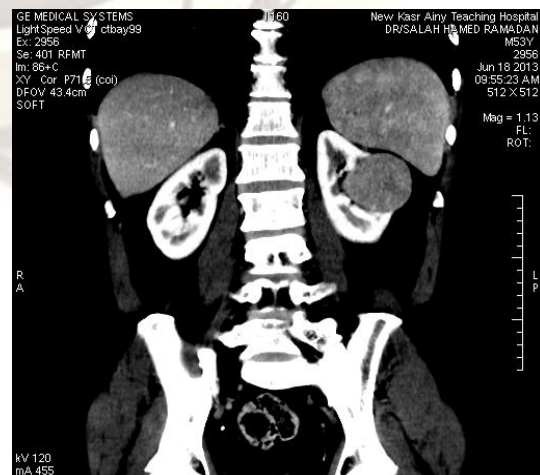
Longitudinal contrast-enhanced CT technique shows lesion of left kidney.
